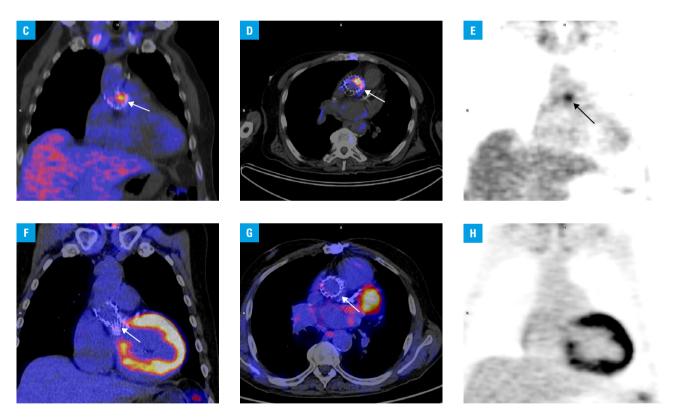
A, B – transesophageal echocardiography performed 2 days after hospital admission, with no signs of infective endocarditis (IE); C–E – fusion images of positron emission tomography/computed tomography (PET/CT) performed in March 2022 for the diagnosis of IE (1<sup>®</sup>F-fluorodeoxyglucose [FDG] PET/CT scan after injection of 326 MBq of 1<sup>®</sup>F-FDG; scan delay, 75 minutes). Arrows indicate the focus of tracer accumulation in the aortic annulus, corresponding to the infection. E – standardized uptake value normalized by lean body mass (SUV lbm) for tissues: valve area SUVmax lbm, 3.9; reference (liver) SUVmax lbm, 3.0; F–H – fusion images of a follow-up PET/CT performed in August 2022 (1<sup>®</sup>F-FDG PET/CT scan after injection of 266 MBq of 1<sup>®</sup>F-FDG; scan delay, 60 minutes). No signs of increased tracer uptake in the aortic annulus were found (arrows). H – SUV lbm for tissues: valve area SUVmax lbm, 2.0; reference (liver) SUVmax lbm, 2.8
